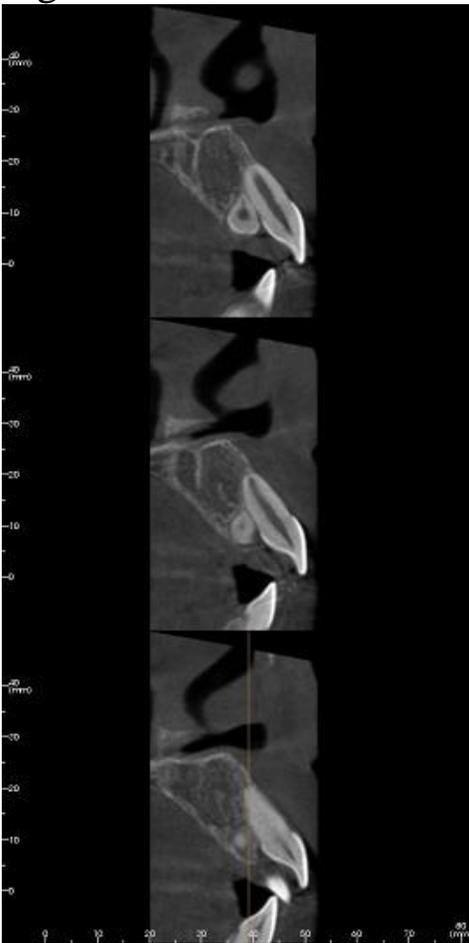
Saggital slice of th CBCT showing the location of the supernumerary tooth towards the tooth 21.
